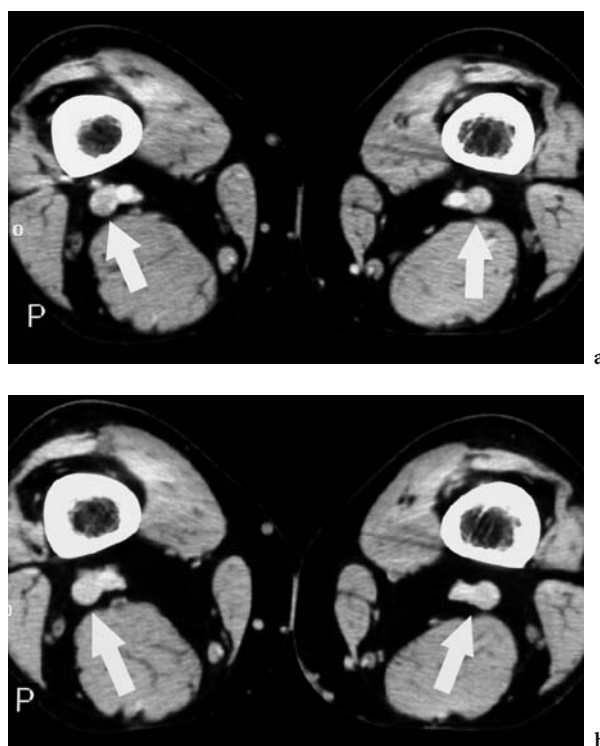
Heterogeneous venous enhancement. a Axial CT venogram at the popliteal level shows a pseudo-filling defect in both popliteal veins (arrows). Scanning was performed less than 180 s after start of contrast medium injection. b Axial CT venogram shows homogeneous enhancement after rescanning 30 s later
